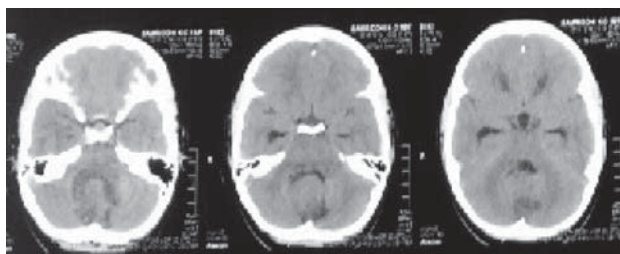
Contrast-enhanced CT scan revealed ill-defined heterogenous solid-cystic in midline posterior fossa. The mass is located in the inferior cerebellar vermis with indistinct margin with the cerebellum.
